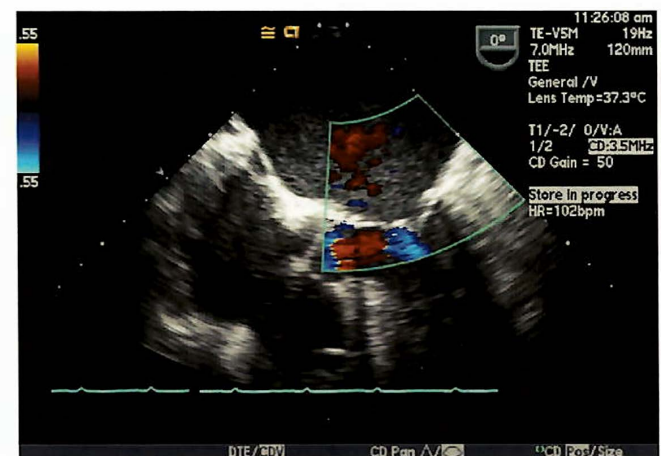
Midesophageal four-chamber view postoperative result with color flow Doppler revealing no mitral regurgitation
